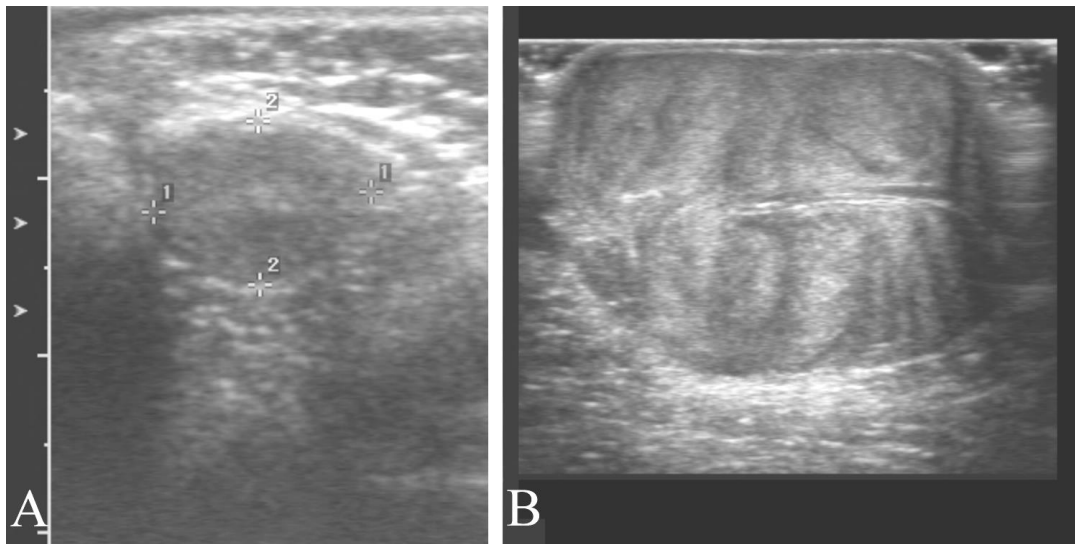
Solid scrotal tumor in a one year nine month old with swelling and prominence of his scrotum. A. Ultrasound of the normal side shows a normal size testicle with normal echogenicity. B. Ultrasound of the abnormal side shows a large heterogeneous mass. Orchiectomy followed, and the lesion was a malignant rhabdomyosarcoma of the peritesticular tissues which had engulfed the testicle.
